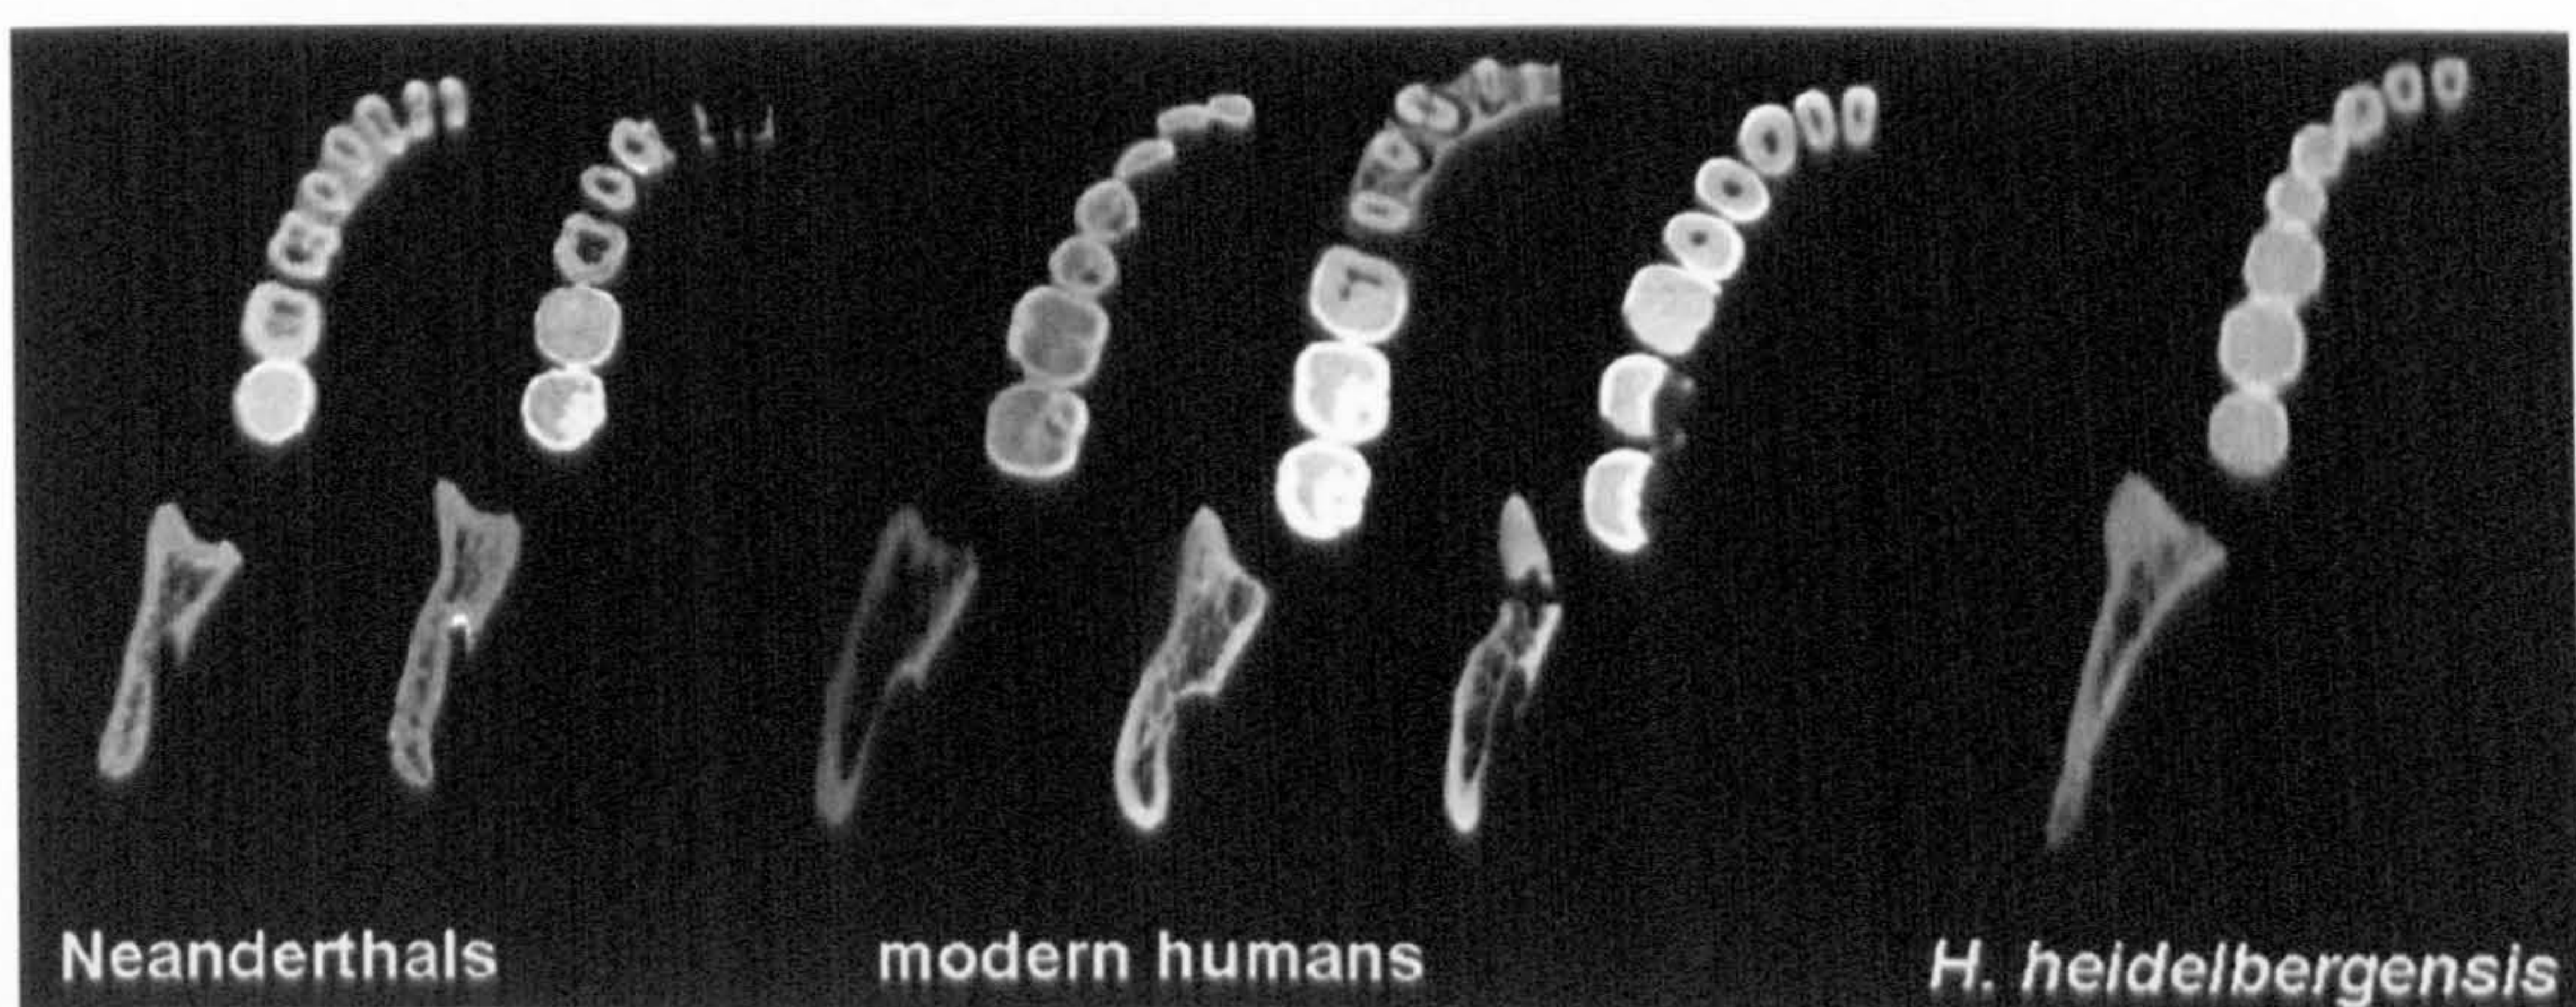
Variation in the distance between molar dentition and ramus, anterior ramus shape and cortical bone distribution within the ramus in modern humans, Neanderthals and *H. heidelbergensis*, as seen in transverse CT slices. Note the more sagittally orientated anterior surface of the ramus in mandibles where the space between molars and ramus is reduced, and the more unequal distribution of cortical bone at the medial and lateral edges of the anterior ramus.
